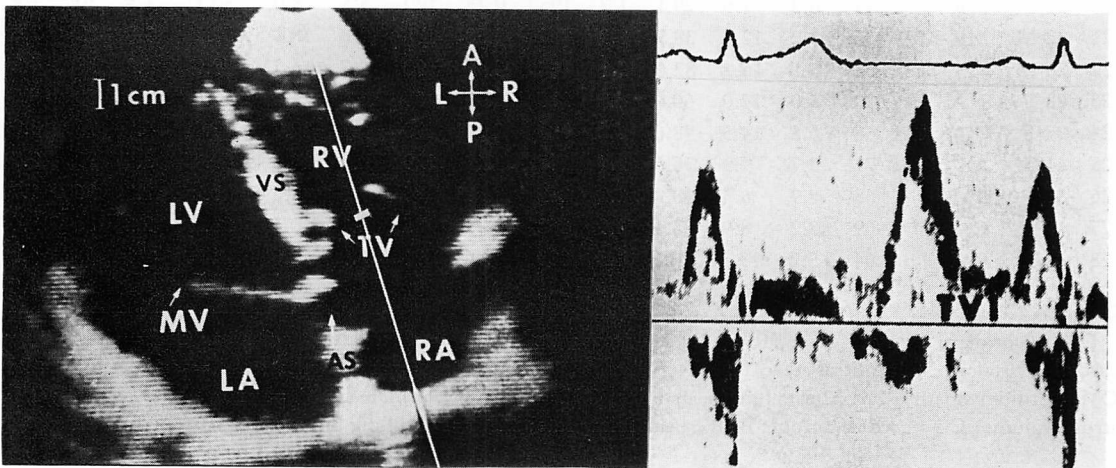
Four-chamber view of the heart obtained from the parasternal view with the sample volume positioned at the plane of the tricuspid annulus, in which the Doppler cursor is aligned parallel to the tricuspid flow (left), and the normal recording of tricuspid Doppler velocity is obtained (right) (paper speed of 100 mm/sec).
